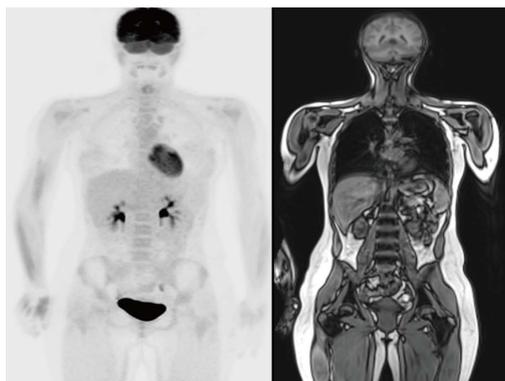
A 17-year-old male with history of Ewing sarcoma underwent follow up whole body positron emission tomography-magnetic resonance imaging which did not reveal any focal abnormal ^{18}F -fluorodeoxyglucose uptake nor was there any focal abnormal marrow signal within the imaged musculoskeletal system to suggest recurrence.
